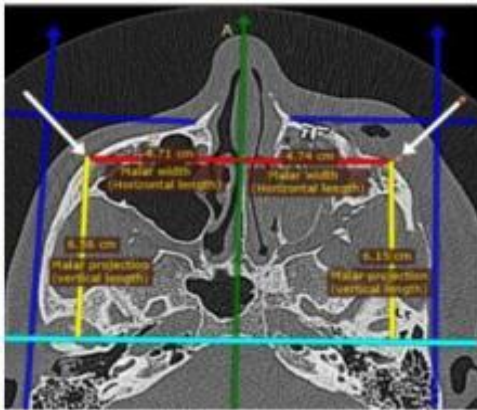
Postoperative radiographic malar width and malar projection on both sides.
